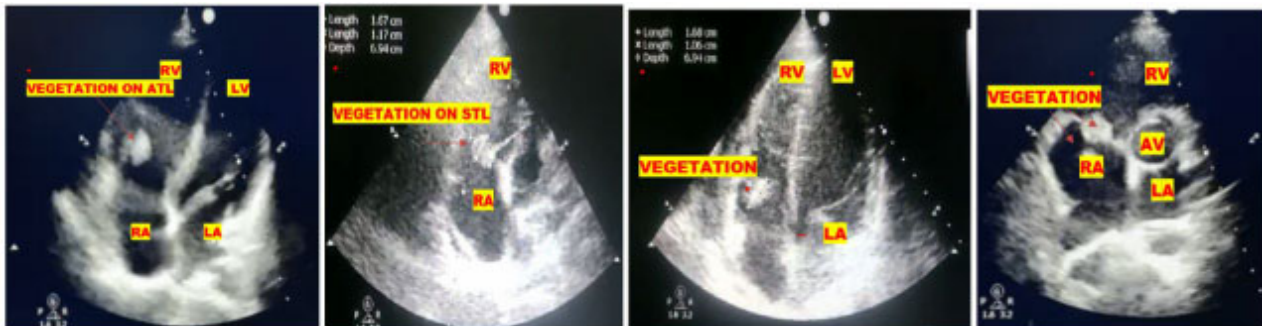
Fig A — Apical 4 Chamber View Showing Vegetation on ATL
